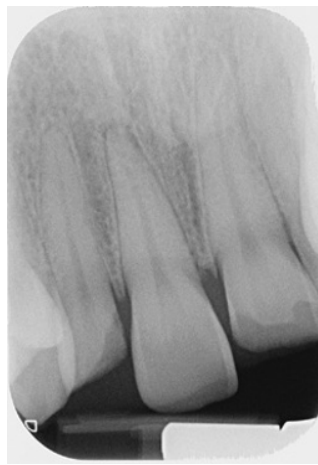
Periapical radiograph confirming intact periodontal ligament, no obvious root fractures and uncomplicated crown fractures UR2 and UL1.
